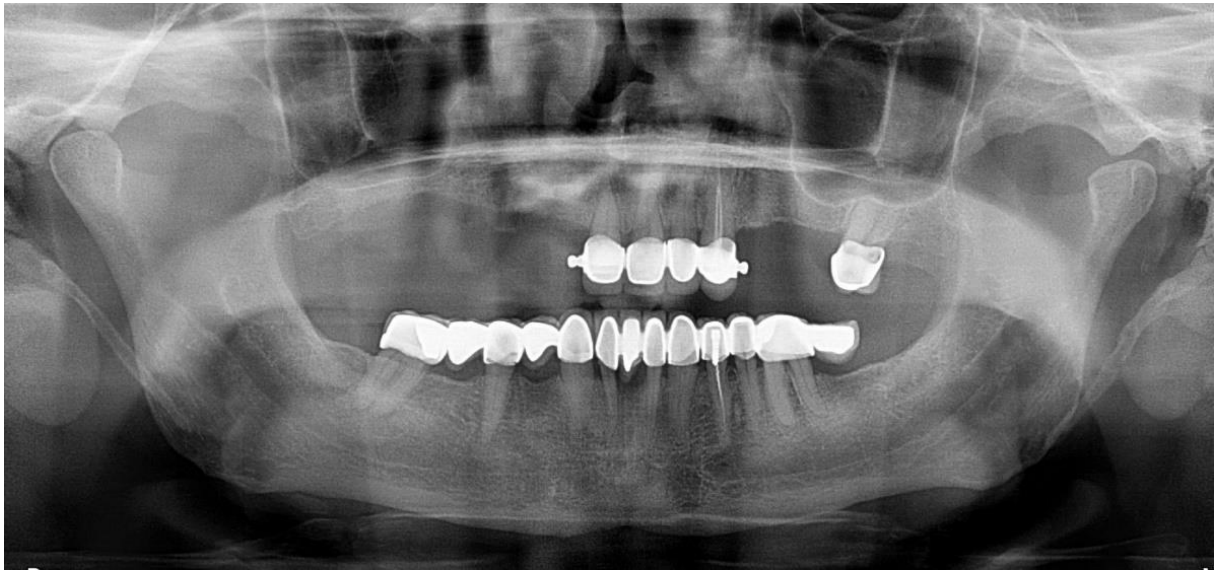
Orthopantomographic image of case 2. Common tooth extractions caused by persistent pain before the diagnosis of TN.
